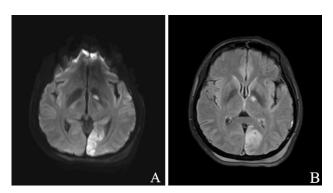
(A) MRI brain, diffusion weighted imaging (DWI), axial section showing restriction in left medial occipitotemporal lobe and medial globus pallidum suggesting left posterior cerebral artery territory infarct; and (B) MRI brain T2 FLAIR sequence, axial section showing hyperintensity in the same areas confirming subacute infarcts.
